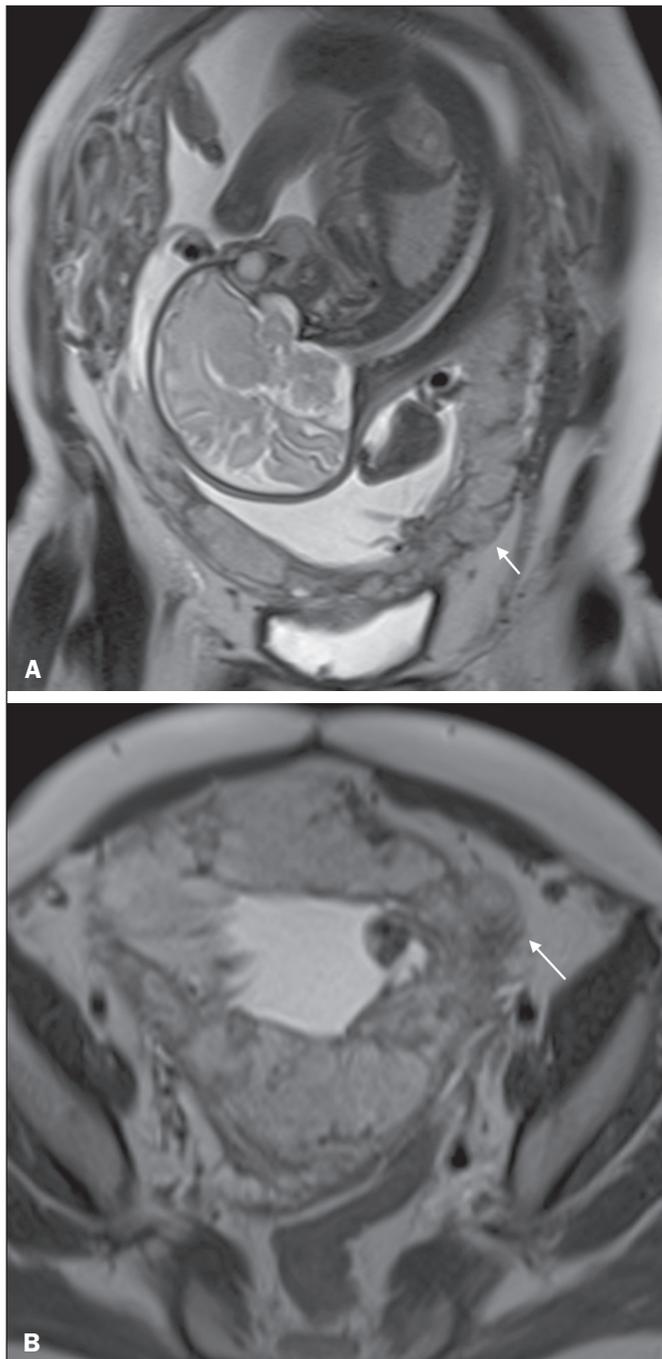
A 35-year-old patient. Coronal T2-weighted HASTE sequence (A) and axial T2-weighted HASTE sequence (B), showing lobulation of the external contour of the uterus in the left anterolateral wall of the inferior portion, with signs of extrauterine extension (arrows), suggestive of placenta percreta.
